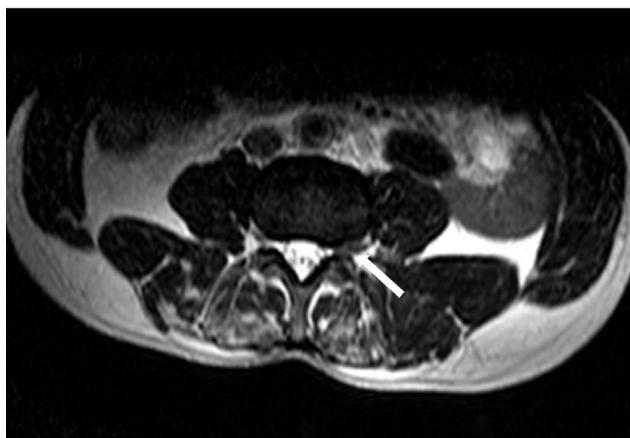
A 55-year-old woman with chronic low back pain. A right paracentral disc herniation was detected at the L5–S1 level on a T2-weighted axial image (white arrow), and bilateral significant lipoatrophy was observed in the multifidus muscle.
